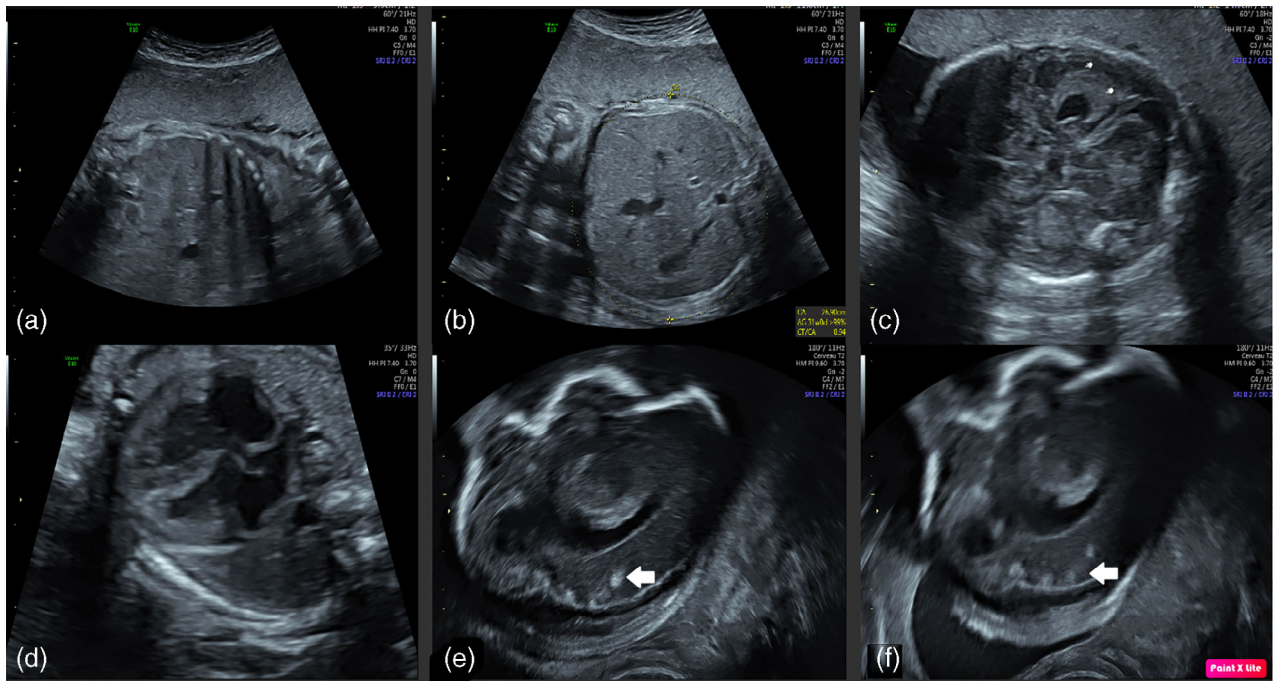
Transabdominal ultrasound performed at 27 GW. (a) Hepatomegaly, liver measured at 55 mm (>p95). (b) Abdominal circumference: 269 mm (>p95). (c) Periventricular hyperechogenicity (fingertip). (d) Four chambers view of the fetal heart showing slight cardiac wall hypertrophy. (e,f) Parasagittal view of fetal right lateral ventricle with multiple 4–5 mm hyperechoic lesions at the cortical–subcortical junction and in the cerebral parenchyma (arrows).
